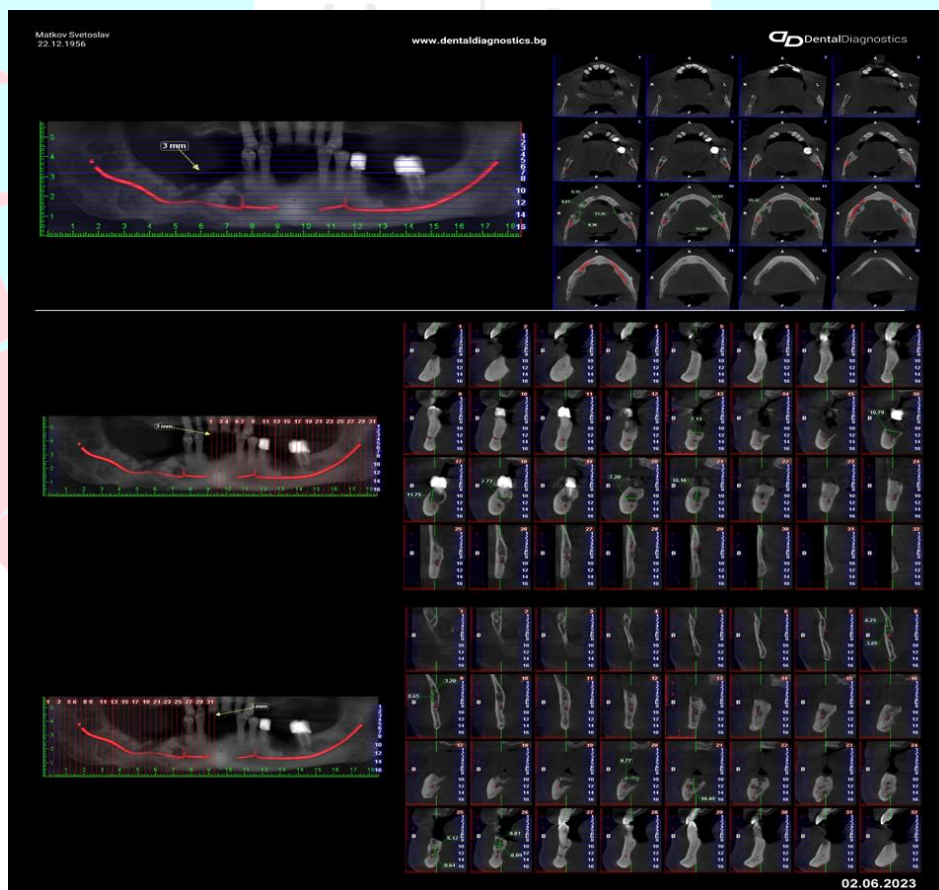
CBCT of the mandible 06.2023.
